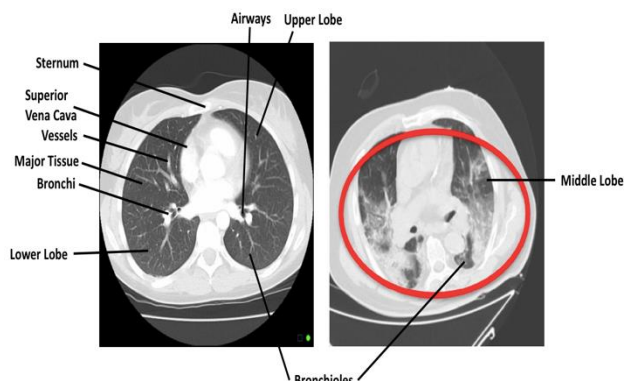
Scanned x-ray image of the lungs before and after being infected with the virus
